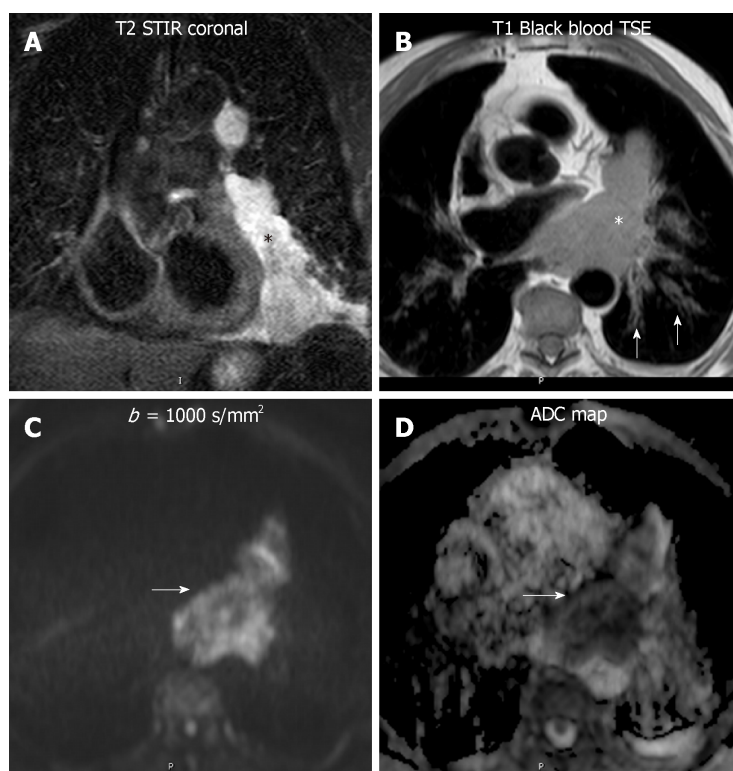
Diffusion weighted imaging of a lymphoma. An 82 year - old man with a paracardiac lymphomatous mass. A: The lesion is hyperintense in short tau inversion recovery (black asterisk); B: On black blood turbo spin echo T1-weighted image, the lesion is slightly hyperintense compared to striated muscle (white asterisk), with infiltration of the pericardium and hilar vessels. Secondary involvement of the left axial interstitium, bilaterally (white arrows on B); C and D: In high b value diffusion-weighted imaging (b : 1000 s/mm²) the mass showed high signal intensity, with low apparent diffusion coefficient: 1.1×10^{-3} mm²/s on the apparent diffusion coefficient map, in keeping with lymphoma (white arrows on C and D). STIR: Short tau inversion recovery; TSE: Turbo spin echo; ADC: Apparent diffusion coefficient.
